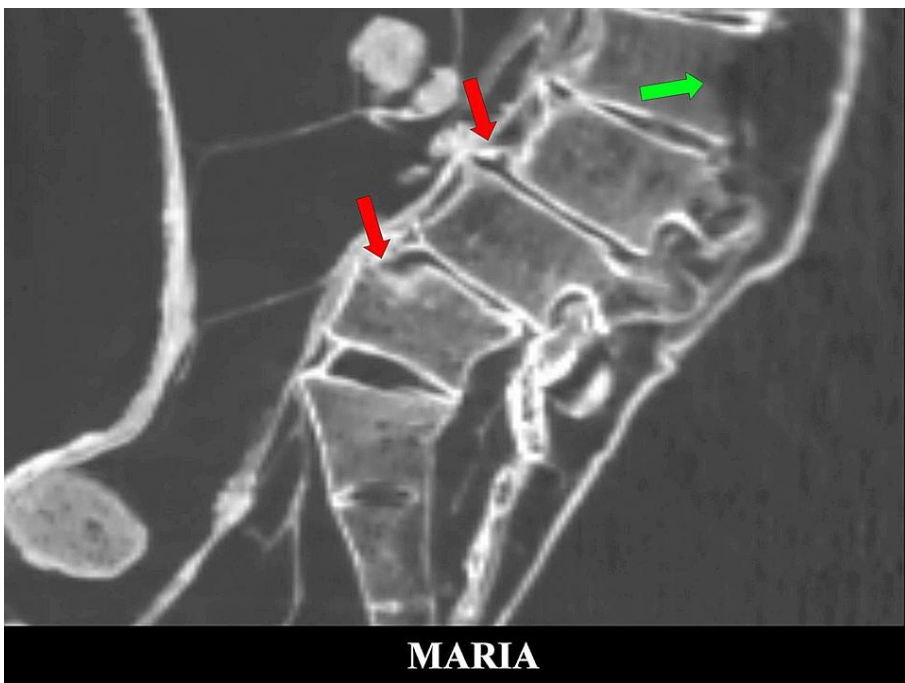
2D CT sagittal scan showing degenerative changes in lumbar spine with retro-spondylolisthesis (*red arrows*) in L3/4 and L4/5, narrowing of intervertebral spaces and spondyloarthropathies. Osteolytic lesion (*green arrow*) in posterior elements of L2 lumbar spine suggestive of cancer with bony secondary.
